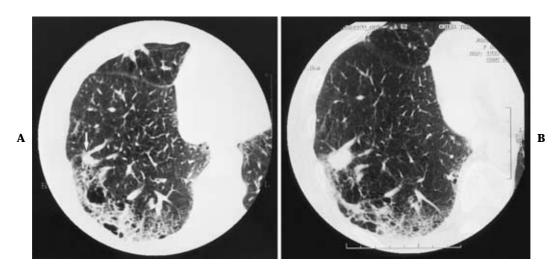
A. A minute area with altered opacity (arrow) can be recognized retrospectively in the right lower lobe by computed tomography(CT)obtained just before the first operation. B. A primary tumor at the same site is evident by CT performed 15 months later.
